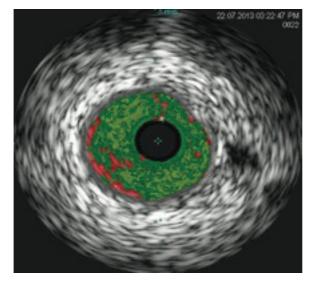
Example of intravascular ultrasound of non-calcified fibro-fatty plaque from HIV positive patient with acute coronary syndrome.
